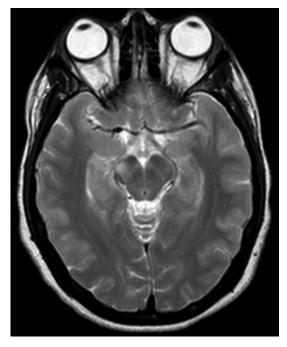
Axial T2-weighted MRI of the brain showing increased T2 signal in the right
